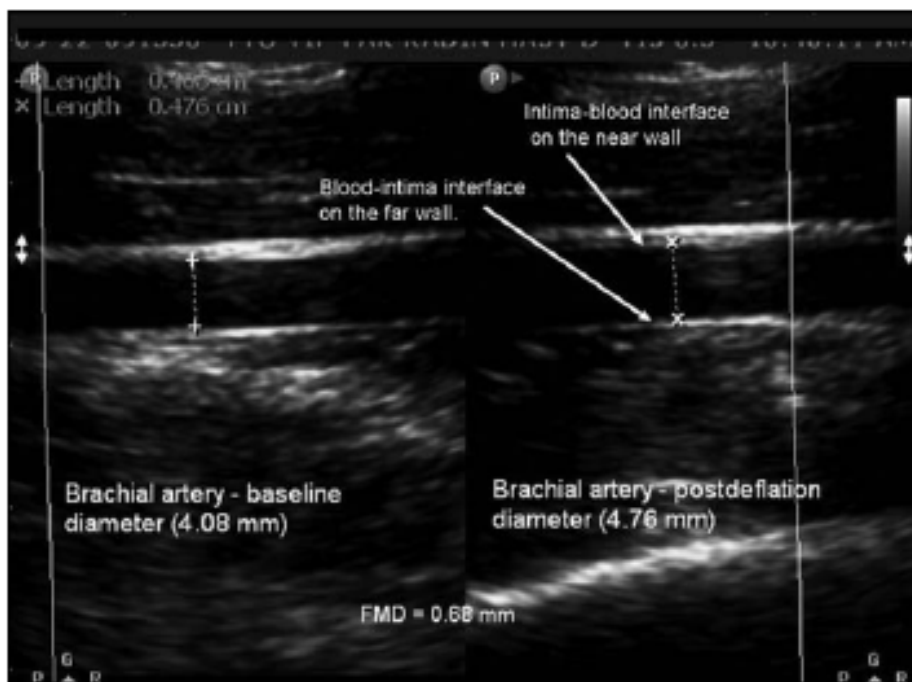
Ultrasound image of the brachial artery. Baseline diameter and postdeflation diameter.
